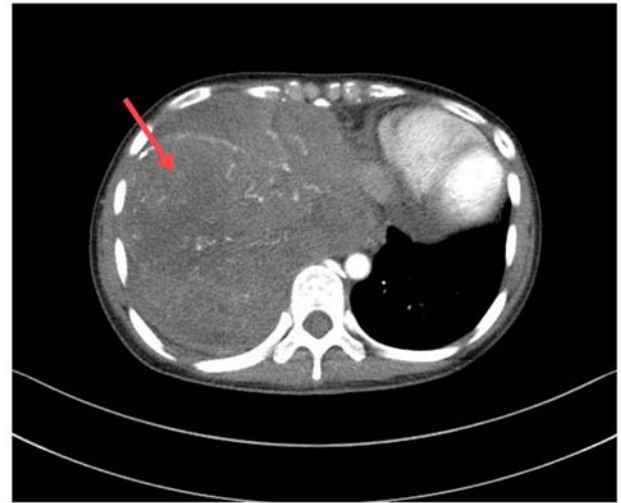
Enhanced computed tomography image showing an irregular mass (red arrow) in the right thorax.
